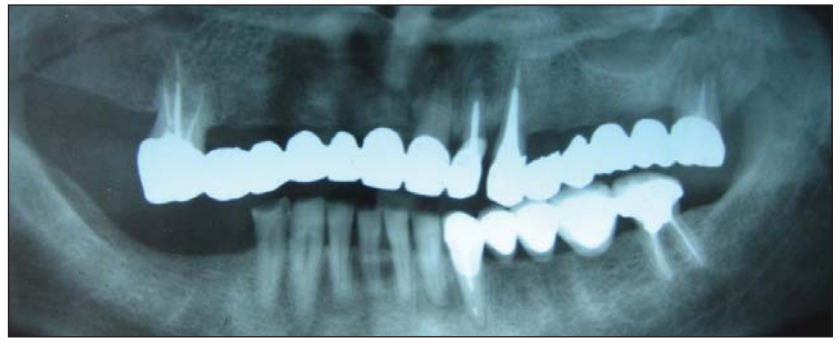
X-ray image at presentation
